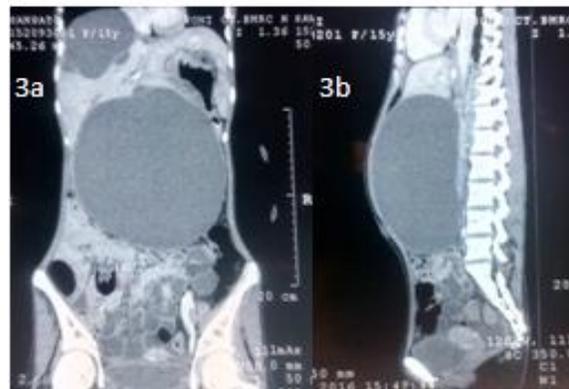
Abdominal CT coronal plane showing two cystic lesions which were found to be communicating on serial slices.
